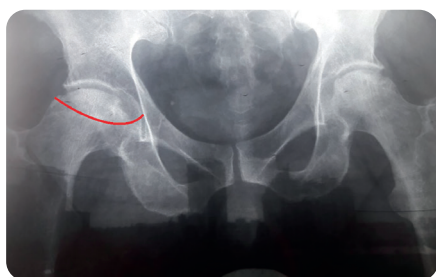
The X-ray image of a patient with right-sided aseptic necrosis of the femoral head with morphometric exclusion criteria for bone tissue donation (the border between the normal and injured area of the femoral head is marked with a red line)
